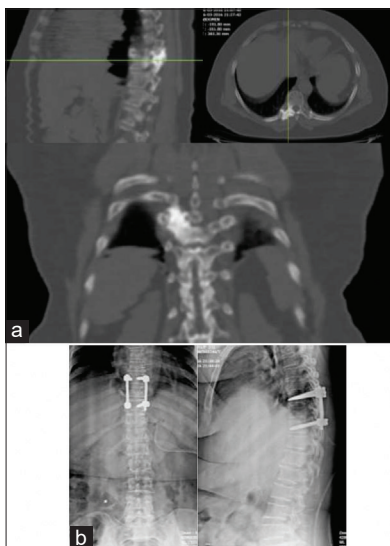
(a) Preoperative CT scan (sagittal/axial/coronal) showing osteoid osteoma involving the right D9 pedicle and lamina. (b) Postoperative X-ray showing pedicle screw stabilization at D8 and D10 level.
